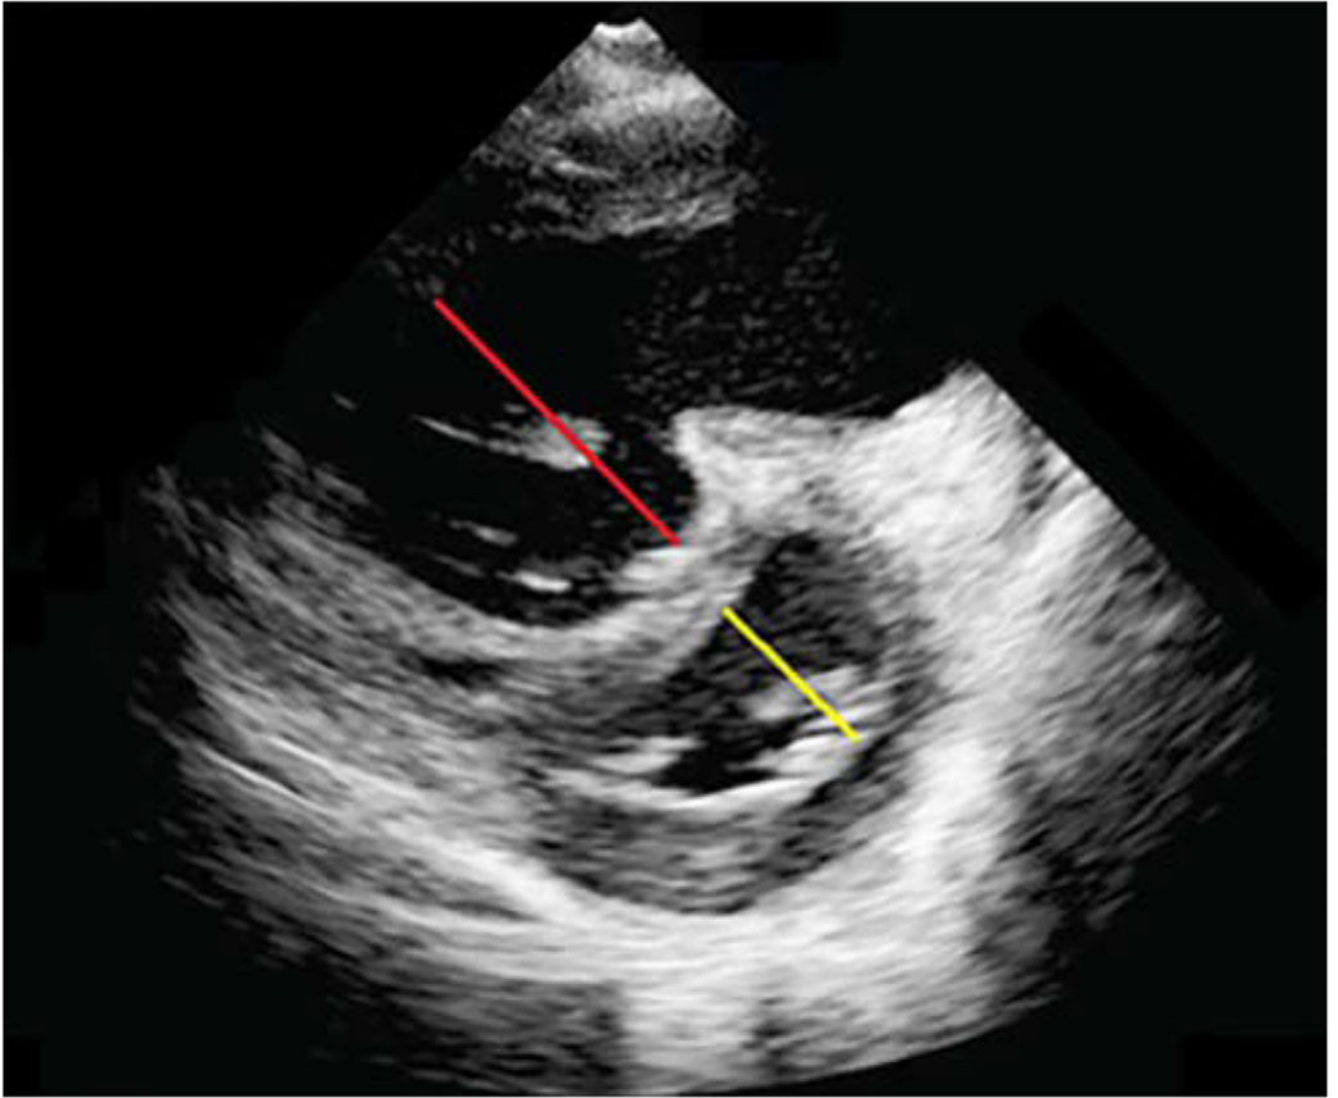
Two-dimensional echocardiogram of a patient with severe PAH in the parasternal short-axis view showing D-shaped left ventricle (yellow line) and severe right ventricular dilatation (red line), along with biventricular remodelling.
